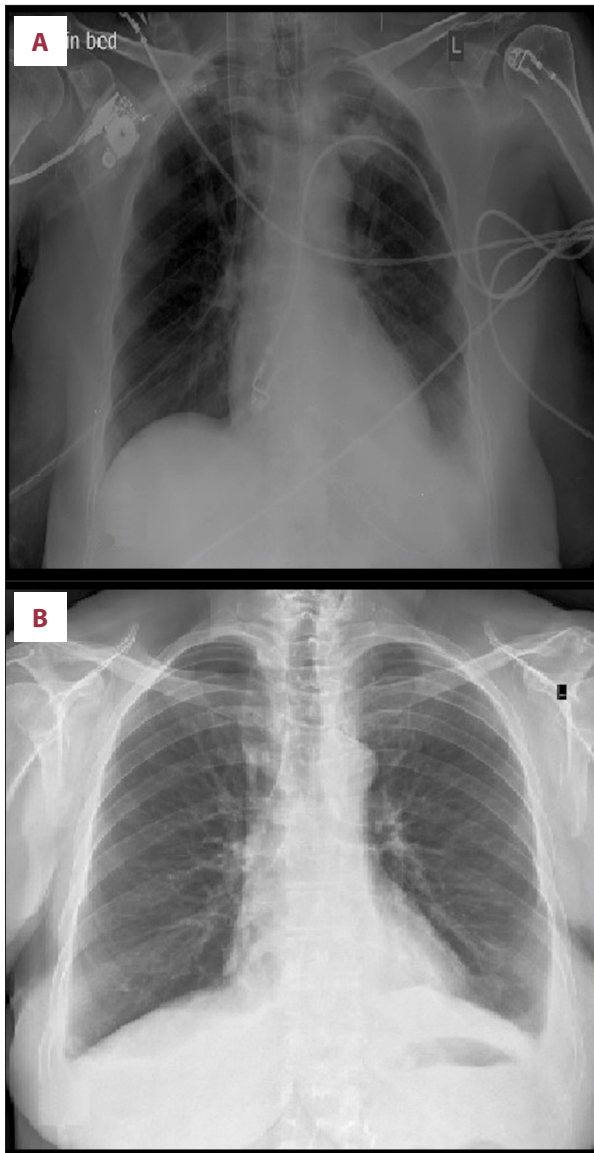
Follow up chest x-ray (CXR) and computed tomography (CT) scan. Marked reduction in the alveolar infiltrates on the CXR 48 hours post-intubation (A) with almost complete disappearance on the discharge day (B) and on a CT scan performed 1 month after (C).
